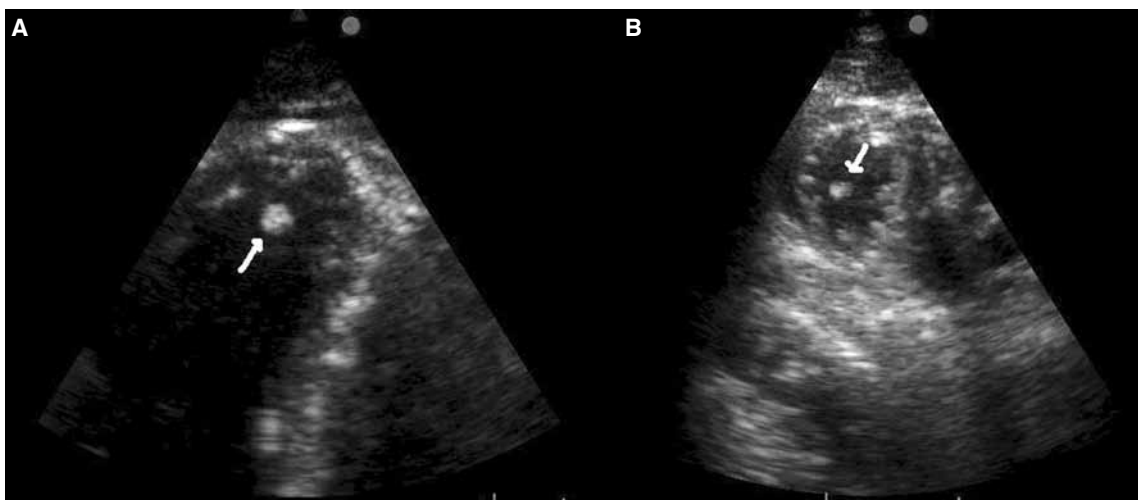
Transthoracic echocardiograms. (A) Apical four-chamber and (B) apical short-axis views showing thrombus remnant (arrow) attached to the left ventricular apex with a very thin stalk.
